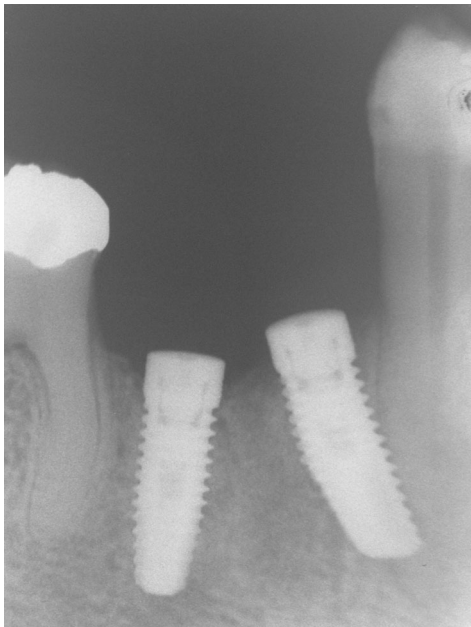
Installation of osseointegrated implants (periapical radiograph)
